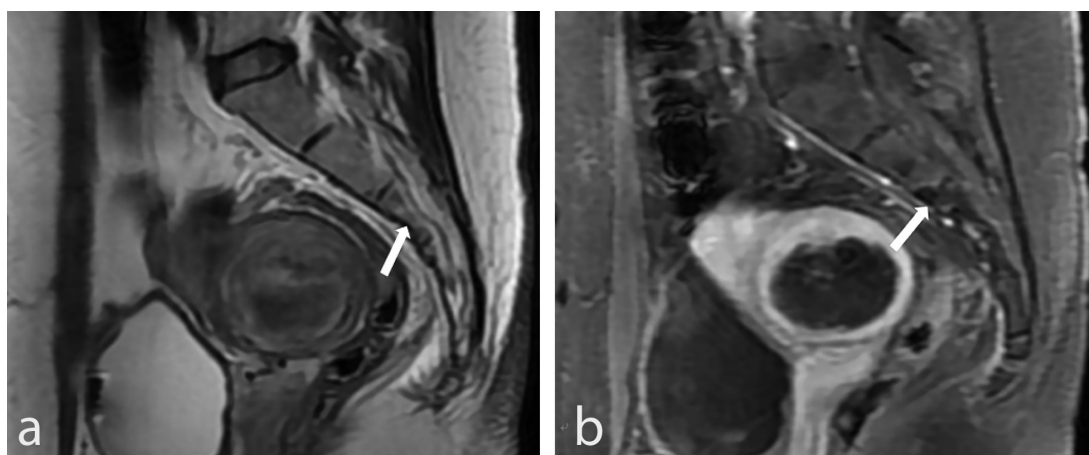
Sacral injury: sagittal view of MRI obtained from a 36-year-old patient with uterine fibroids after high-intensity focused ultrasound showed normal morphology and structure in the sacrum. (a) The postoperative T2WI showed a strip-shaped high–low mixed signal intensity of the 2nd–4th cones in the sacrum (arrow). (b) The postoperative contrast-enhanced MRI showed a non-enhanced area (arrow). MRI, magnetic resonance imaging.
